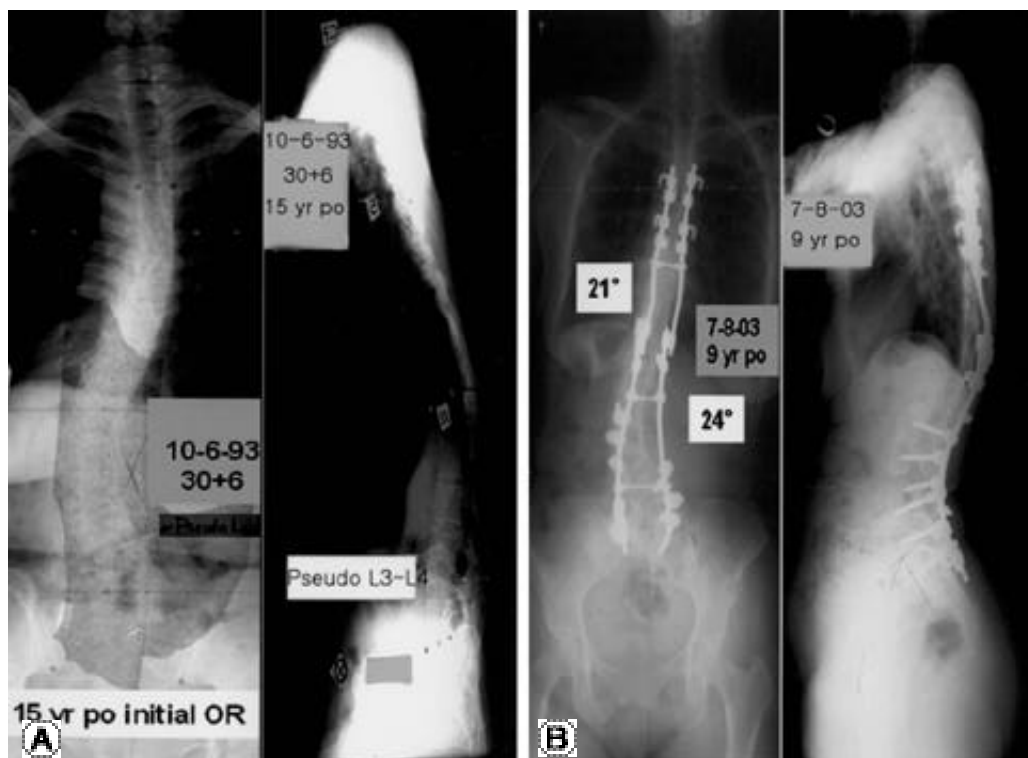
An example of multiple Smith-Petersen osteotomies. (A) Preoperative long-cassette standing coronal radiograph and sagittal radiograph (B) Postoperative long-cassette standing coronal radiograph and sagittal radiograph showing excellent correction of the sagittal deformity, but worsening of the coronal balance.
